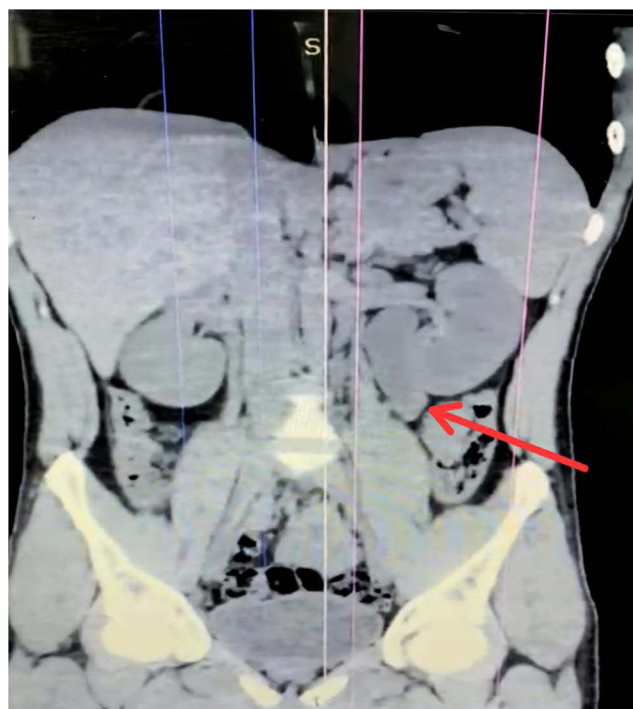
Non-contrast coronal CT reformat showing pronounced left hydronephrosis with proximal ureteral dilatation. The arrow indicates a focal intraluminal soft-tissue density within the upper ureter associated with proximal ureteral dilatation.
